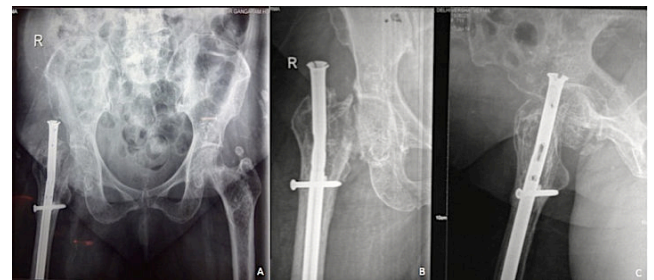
(A) Antero-posterior roentgenograph of both hips with pelvis showing fracture neck of the right femur (B) Antero-posterior roentgenograph of right hip in internal rotation (C) Antero-posterior roentgenograph of right hip in external rotation showing un-united fracture neck of femur.
